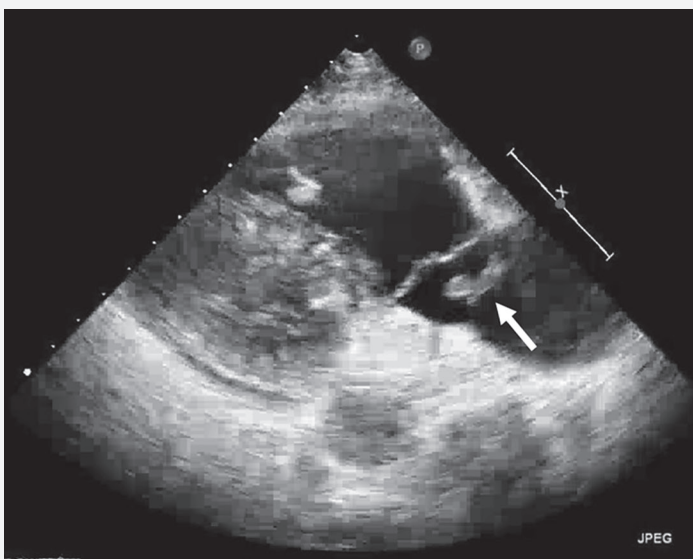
Echocardiogram in a right ventricular inflow view showing right atrial thrombus (white arrow)
